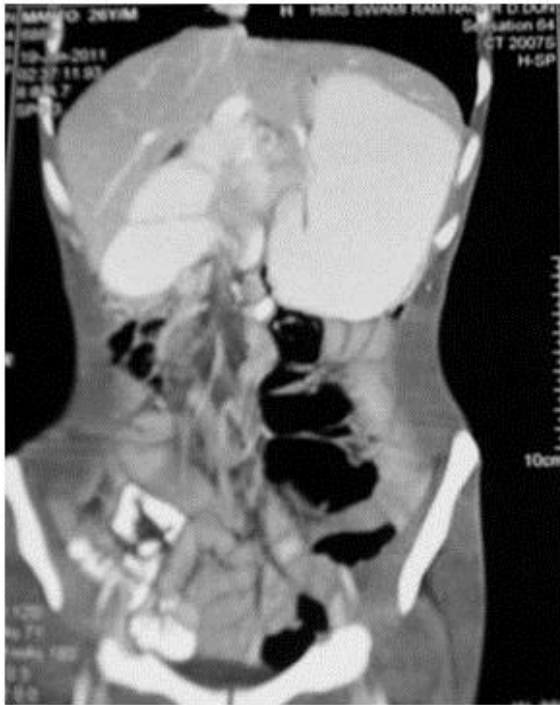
Contrast-enhanced CT scan of abdomen showing proximal dilatation of duodenum and stomach suggestive of duodenal obstruction.
